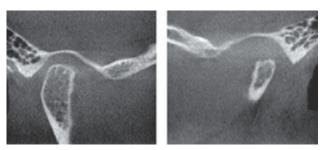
Corrected sagittal CBCT sections of left condylar hypoplasia compared to normal right condyle.
